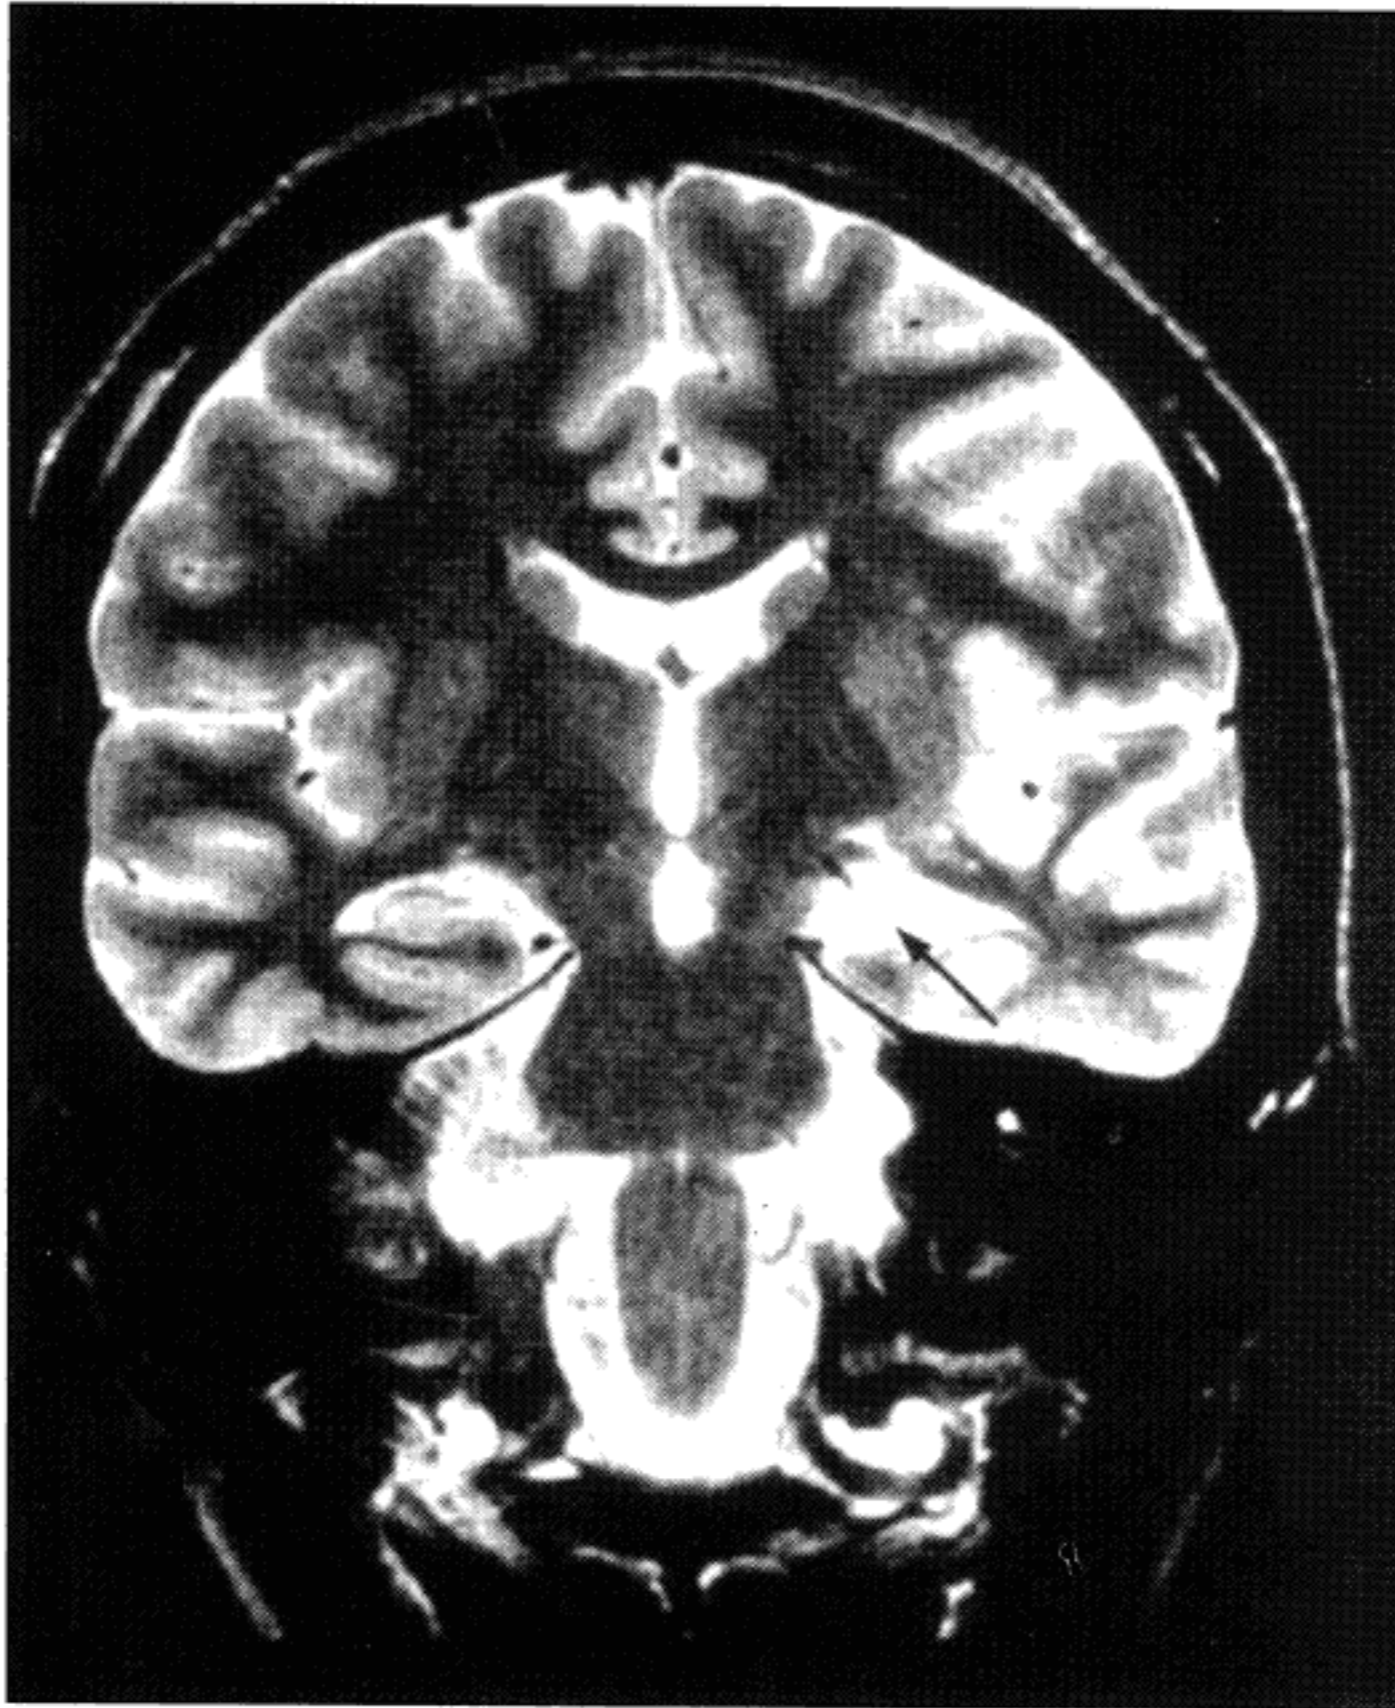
T2-weighted coronal MRI showing increased signal intensity in the region of the left hippocampal body.
